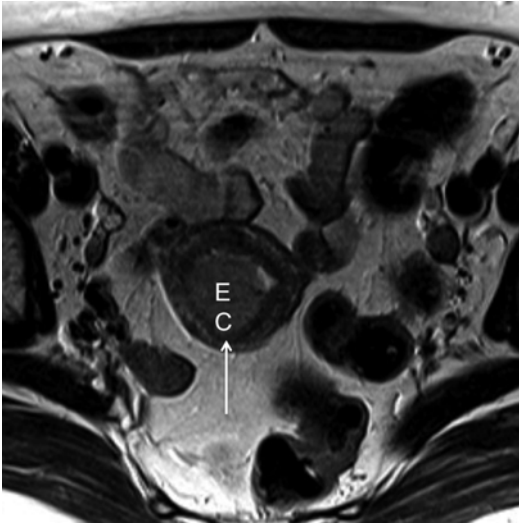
Risk of overstaging the depth of myometrial infiltration. On this axial TSE T2-weighted image (TR/TE 2,400/76 ms), a large polypoid endometrial carcinoma (EC) is clearly appreciable. The calculated percentage of myometrial infiltration exceeds 50 %, but it is important to notice that the junctional zone shows no interruptions in the site involved by the neoplasm. Therefore, the >50 % reduction of myometrial thickness in that site must be considered a consequence of compression and not of infiltration by the neoplasm. In such conditions the neoplasm must be classified as MRI stage Ia, despite the measured values of myometrial infiltration
